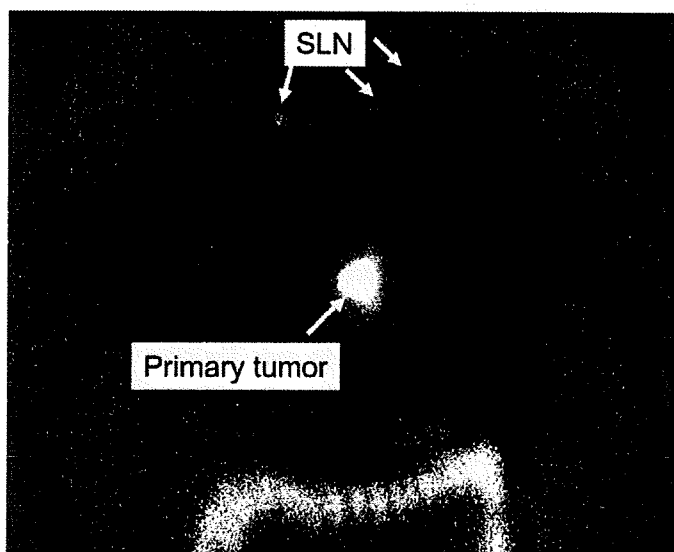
Preoperative lymphoscintigraphy for thoracic esophageal cancer.
